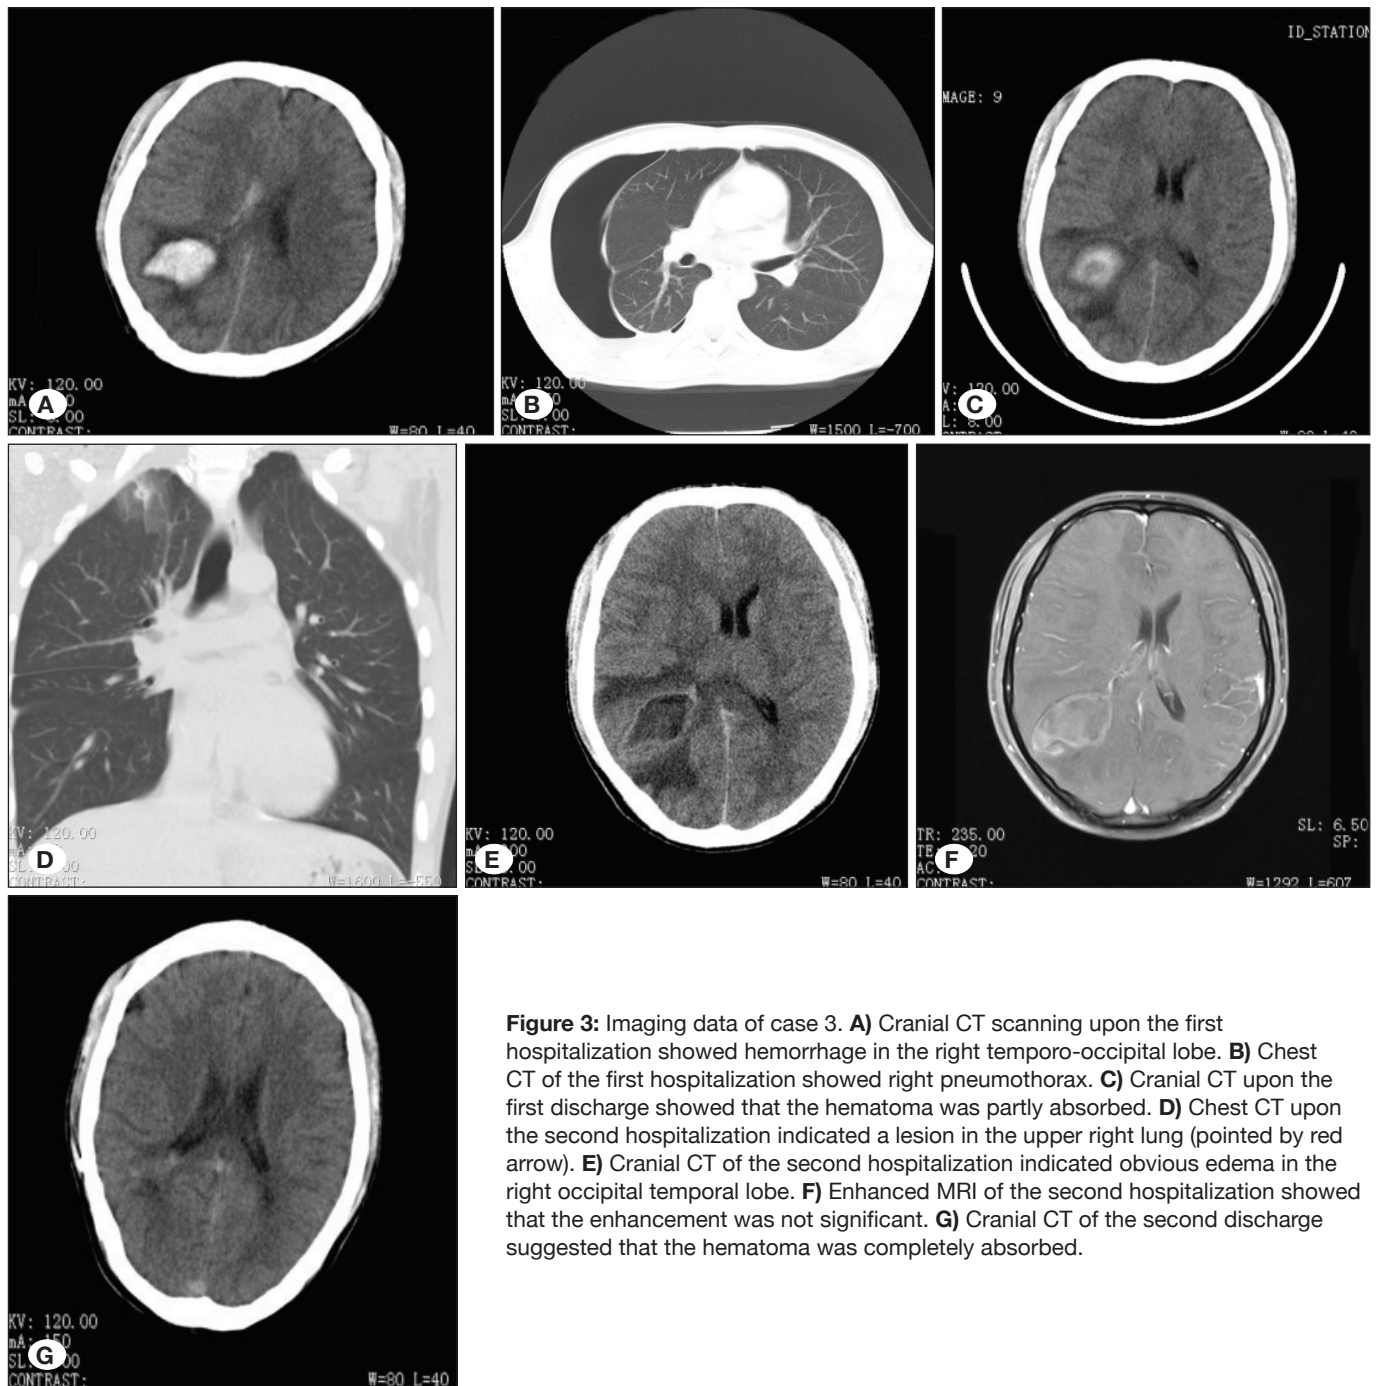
Imaging data of case 3. A) Cranial CT scanning upon the first hospitalization showed hemorrhage in the right temporo-occipital lobe. B) Chest CT of the first hospitalization showed right pneumothorax. C) Cranial CT upon the first discharge showed that the hematoma was partly absorbed. D) Chest CT upon the second hospitalization indicated a lesion in the upper right lung (pointed by red arrow). E) Cranial CT of the second hospitalization indicated obvious edema in the right occipital temporal lobe. F) Enhanced MRI of the second hospitalization showed that the enhancement was not significant. G) Cranial CT of the second discharge suggested that the hematoma was completely absorbed.
